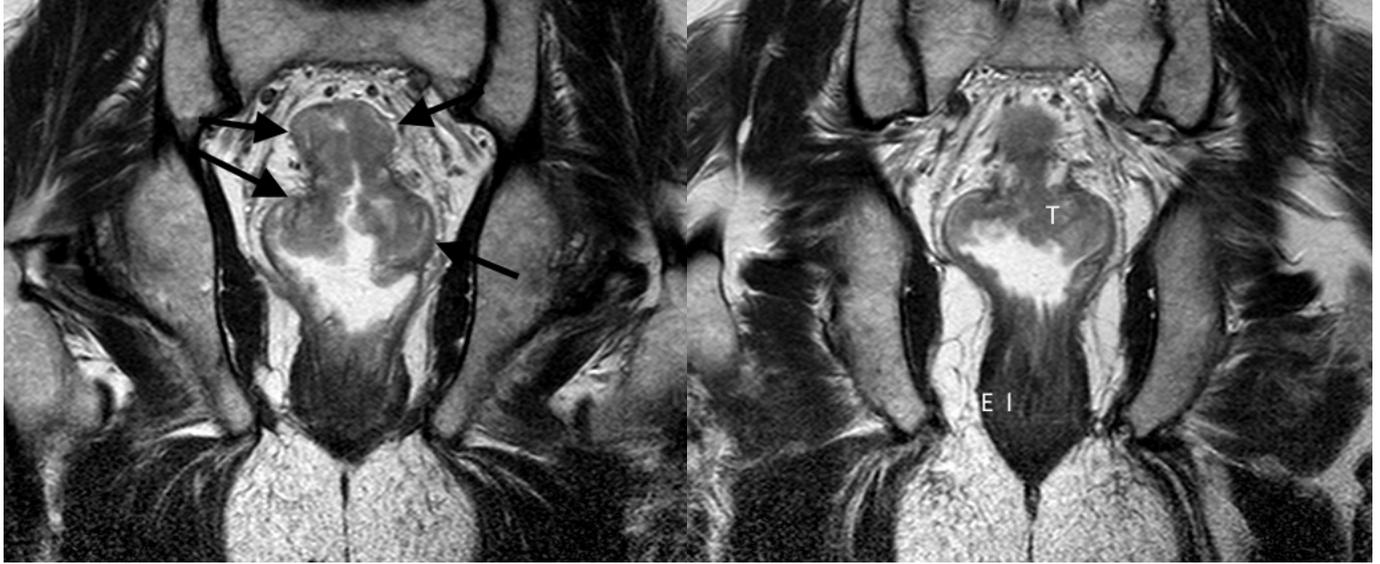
a. Coronal image T2-weighted MR scan through the rectum showing a rectal cancer (arrows). The level of the cancer is best assessed on sagittal and coronal images. Case courtesy of Dr Natalie Yang, Radiopaedia.org, rID: 7124. b. Sparing of the internal (I) and external (E) anal sphincter is best confirmed on coronal T2-weighted images. (T – tumour) Case courtesy of Dr Natalie Yang, Radiopaedia.org, rID: 7124.
